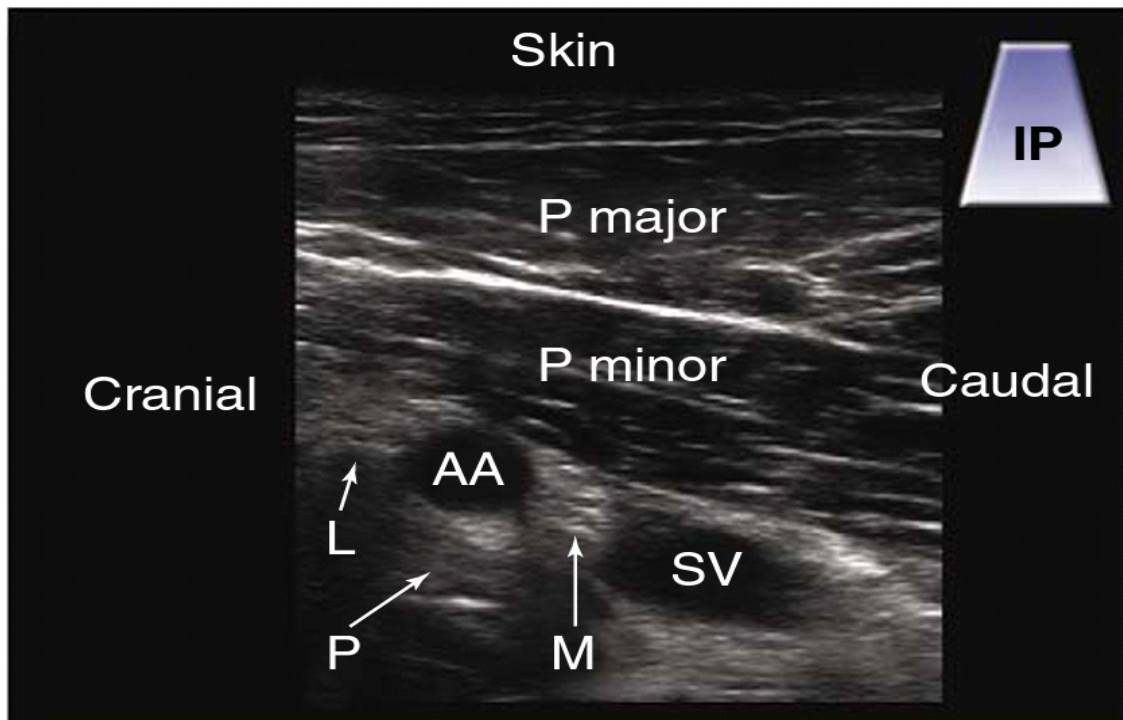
Sonographic image of infraclavicular brachial plexus
